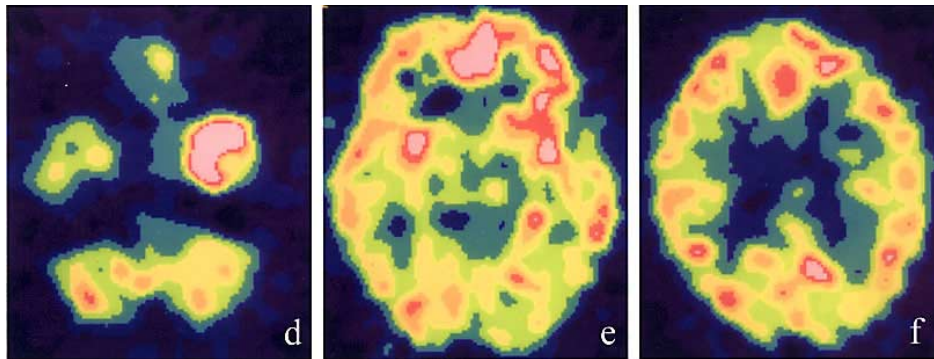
(d–f) SPECT images at 36 days after onset showed localized increased uptake in the left medial temporal lobe, left insular cortices, and cingulate gyri.
